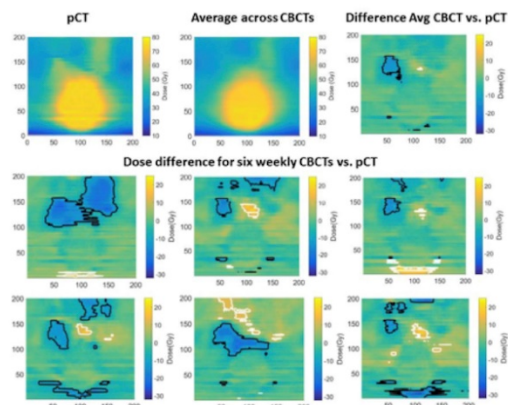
Rectum dose surface maps for the planned dose distribution (pCT) as well as from the averaged dose maps (average across CBCTs). The top right map is the difference maps between these two (Average CBCT vs pCT) where dose differences larger than +/- 10 Gy (scaled to the full treatment dose) are indicated (dose increase during RT in white; dose decrease in black). The six maps in the lower part of the figure are the dose difference maps for six weekly CBCTs relative to the pCT (white/black contour as in the other map).
